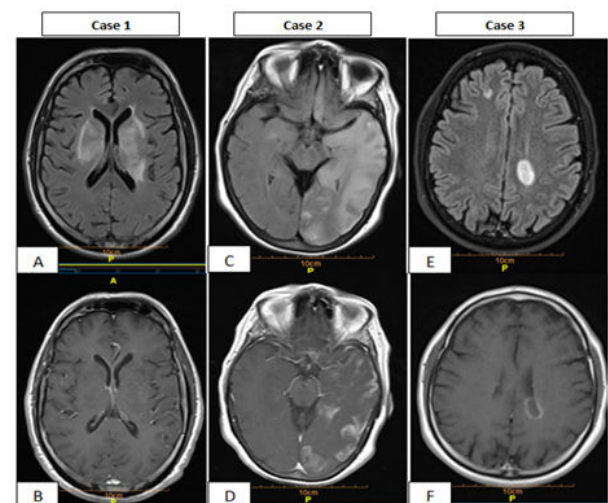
Brain MRI of 3 cases with and without contrast; Fig 1-A, B: symmetrical T2/FLAIR increase signal intensity. Fig 1-C, D:
